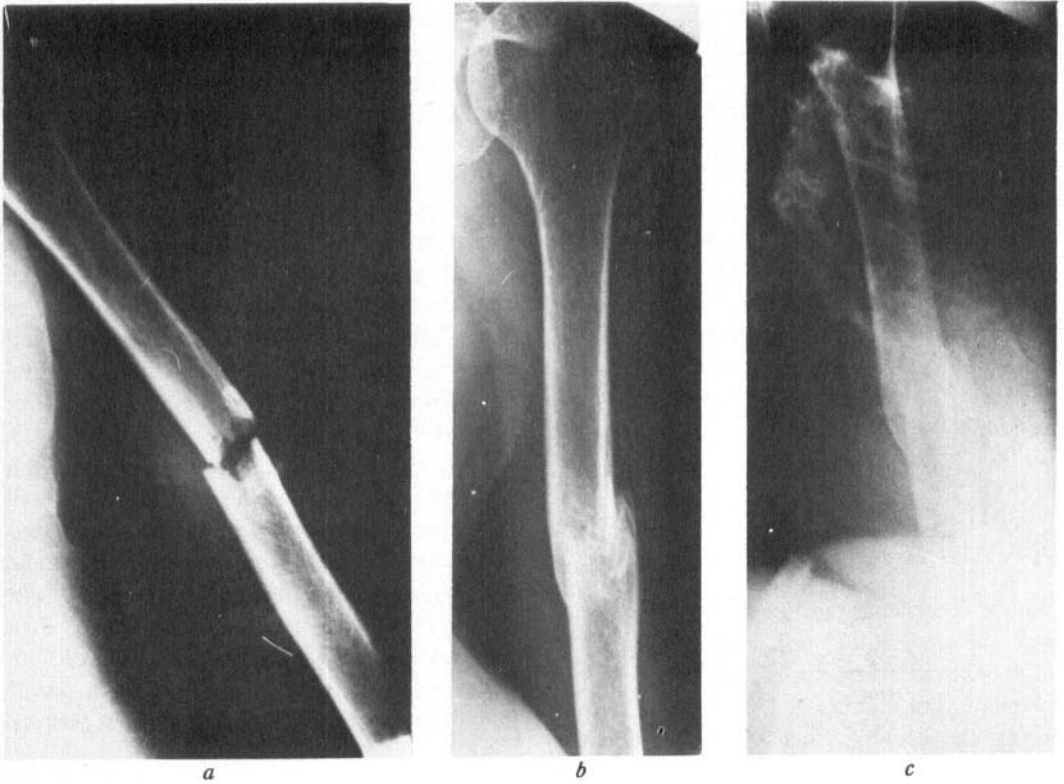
(a) Transverse fracture of the left humerus (January 6) in a 77-year-old woman. (b, c) X-rays of the patient at follow-up on October 15. Position of fracture had not changed since January 21, when the mobility of arm had been so good that the patient was satisfied and declined further treatment.
